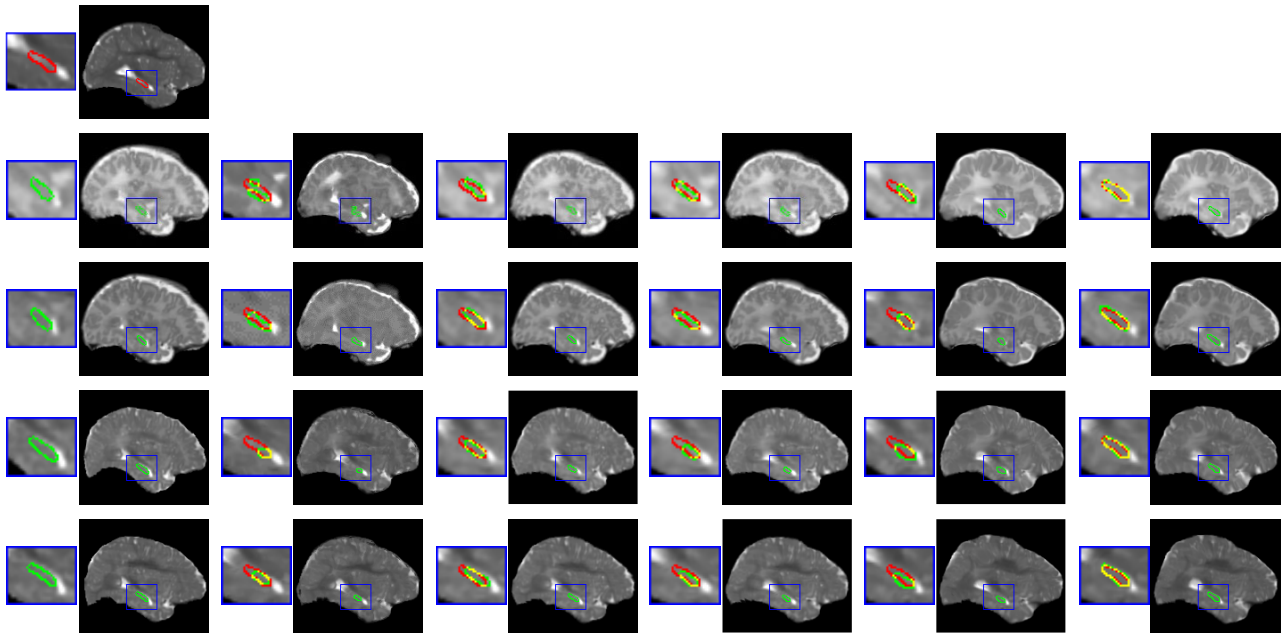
Visualization of the intersubject registration of T2-weighted MR images. The sagittal slices are in the same order as in Fig. 5. Our proposed method can realize the largest hippocampus overlaps (shown in the last column).
